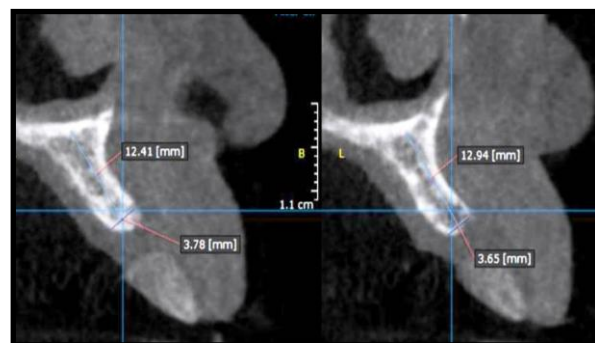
CBCT analysis of maxillofacial structure enables clinician to accurately plan the site of implant placement with implant dimension.
